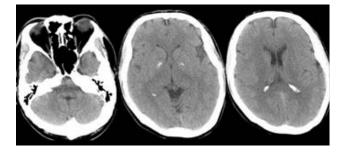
Head computed tomography (CT) (Head CT shows hyperostosis of the cranial vault with calcification at the globus pallidus and choroid plexus)
